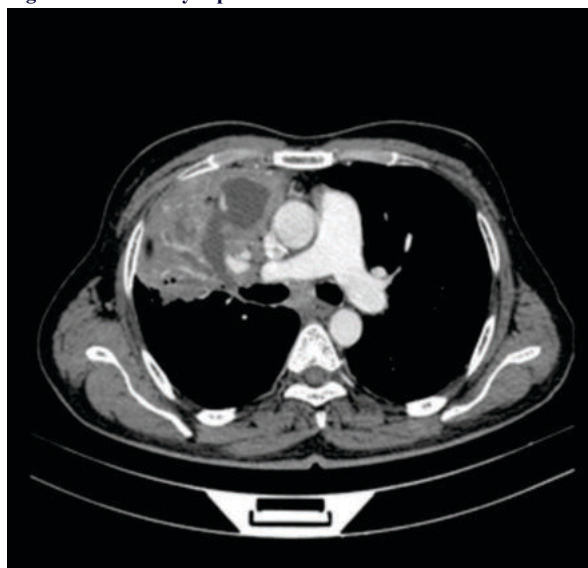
Computed Tomography Thorax at presentation
